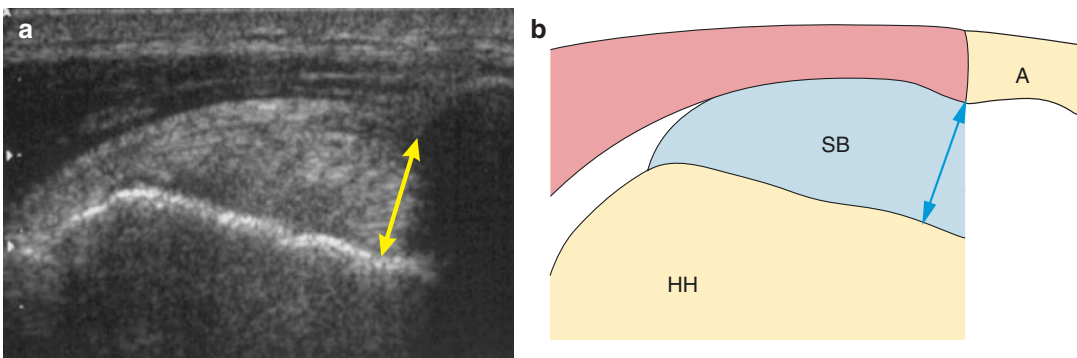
Sonographic measurements of the acromiohumeral distance
